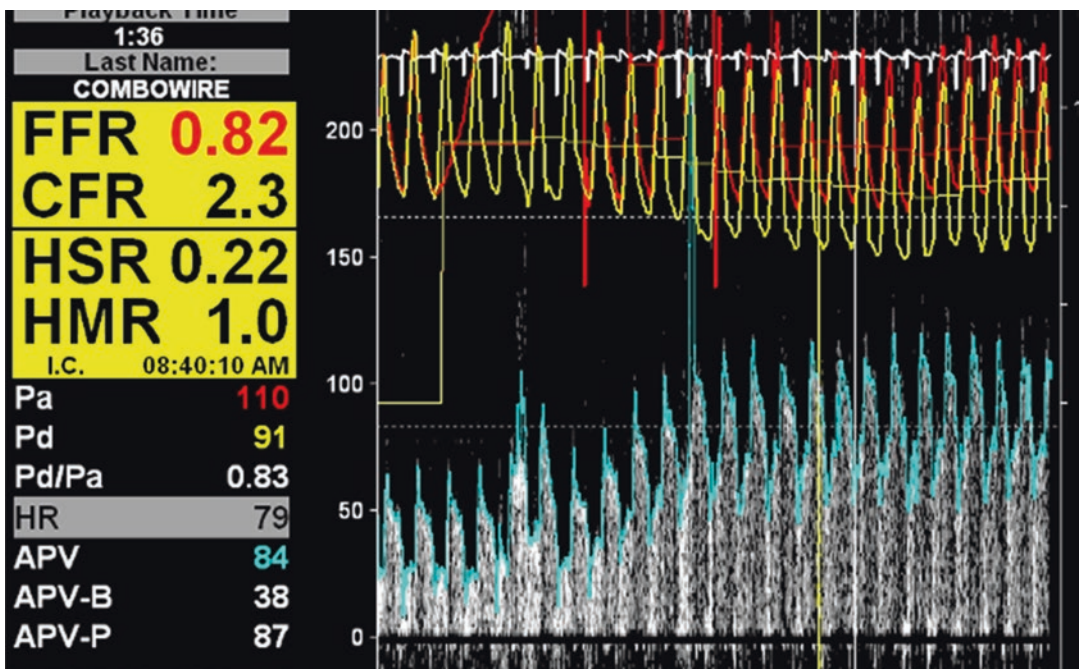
Combination FFR and CFR assessment with combination pressure and Doppler flow wire. *HSR* hyperemic stenosis resistance, *HMP* hyperemic myocardial
